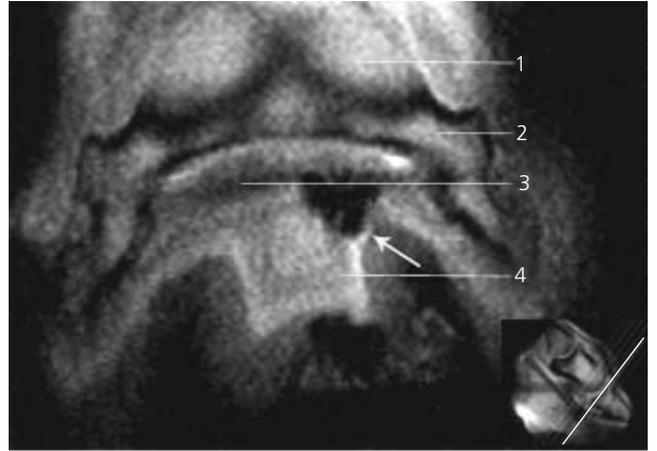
T1-weighted transverse oblique image of Case 3 taken distal to the navicular bone 2 days post injury. The area of hypointensity seen on Figure 5 is evident here overlying the medial deep digital flexor tendon. 1 = Middle phalanx; 2 = distal phalanx; 3 = deep digital flexor tendon; 4 = cuneal part of digital cushion.
